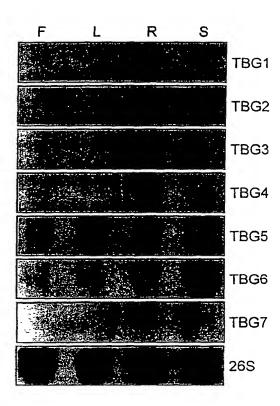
Autoradiograph of northern blot analysis of TBG expression in various plant tissues. Twenty μg of total RNA extracted from flowers (F), leaves (L), roots (R) and stems (S) was loaded in each lane. RNAs were separated in an agarose gel and transferred to nylon membrane. Blots were hybridized using the probes indicated to the right, washed to a final stringency of 0.1X SSC at 65°C and were used to expose x-ray film. A 26S ribosomal gene clone from soybean was used as a loading control for each blot and one example is shown.
